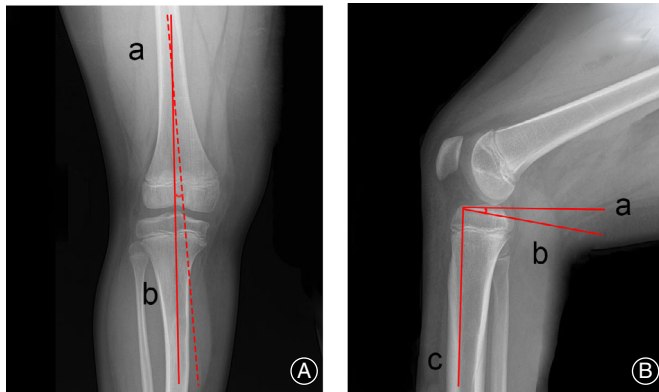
(A) The femorotibial angle is obtained on the antero–posterior radiograph by measuring the angle between the longitudinal axis of the femoral shaft (a, dotted line) and the longitudinal axis of the tibial shaft (b, solid line). (B) The posterior tibial slope is obtained on the lateral knee radiograph by measuring the angle between an axis drawn perpendicular to the anatomical axis of the tibia (a) and a line parallel to the tibial plateau (b).
